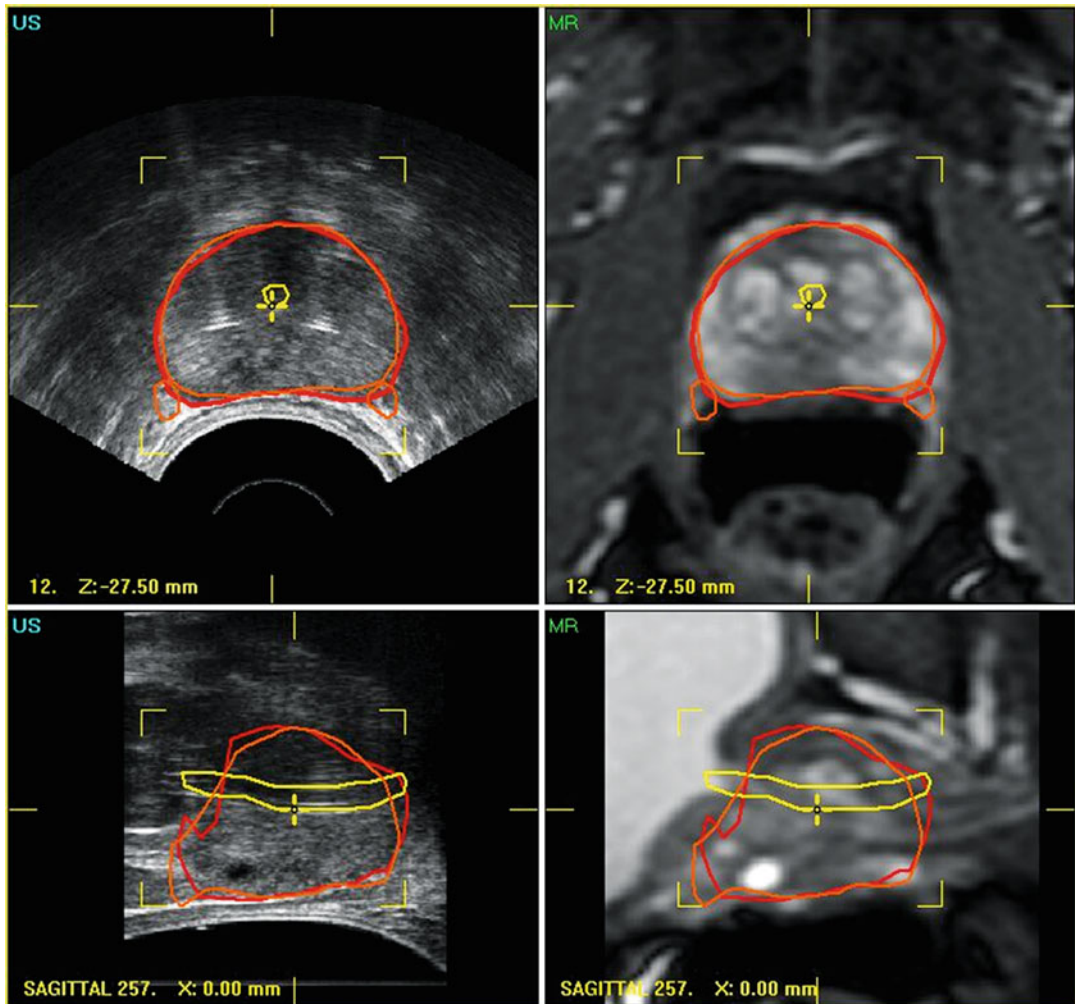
Slice with contour of the prostate with TRUS in transversal and sagittal direction. Similar for MRI (*right side*). *Red line* is contour obtained from TRUS, *orange line* is contour from MRI with also neurovascular bundle
